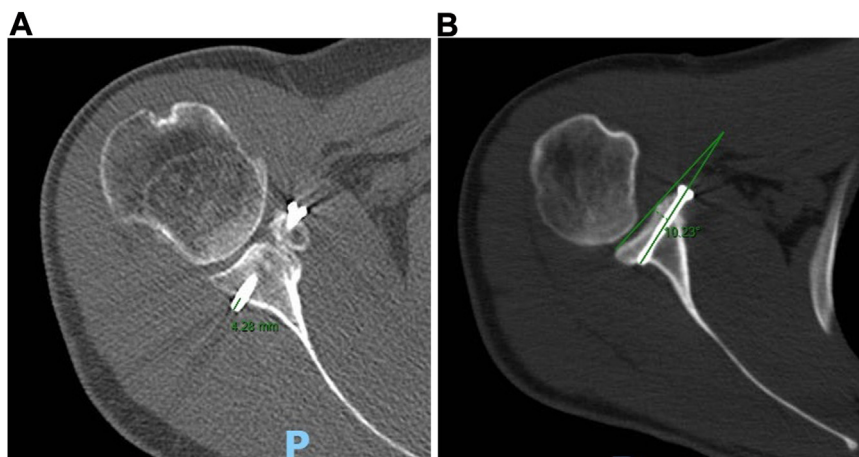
(A) Measurement of the distance from the posterior cortex of the scapula and the tip of the screw (—). (B) Axial view of the right shoulder in a postoperative CT scan. Example of α angle measurement (—): the line tangent to the anterior and posterior margins of the glenoid and the line drawn along the length of the screw. CT, computed tomography.
